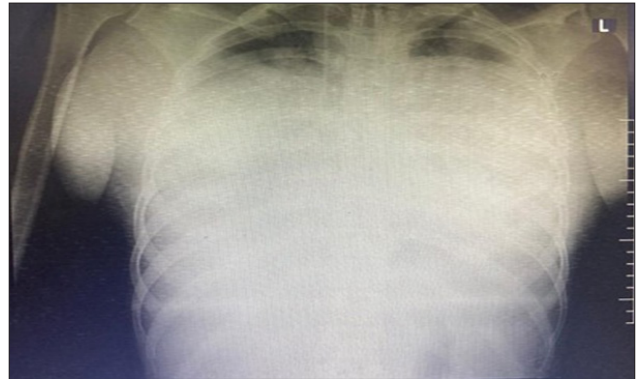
PA View of Chest X-Ray showing Bilateral Pleural Effusion
